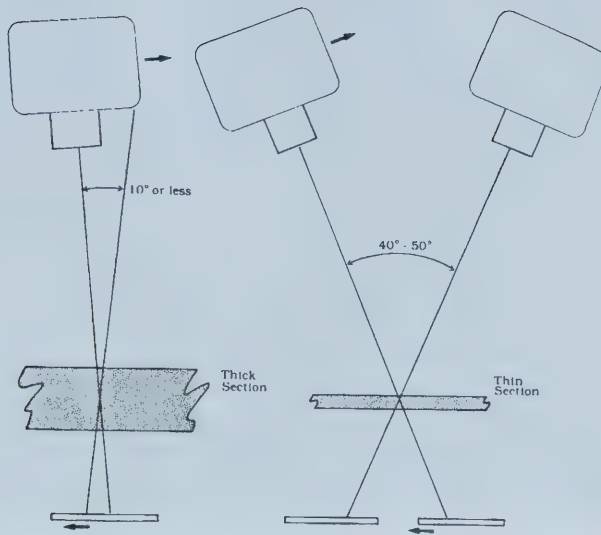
Image Generation in Tomography. The x-ray beam source moves in one direction, while the film cassette moves in the opposite direction. Note that the angles of exposure determine the thickness of the tomographic plane. (From Langland OE et al. 2002; 11: 277)
